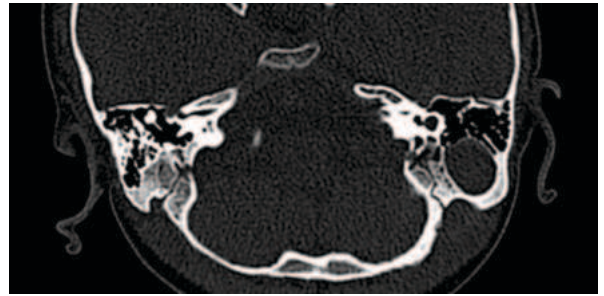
Axial CT image showing right cochlear aplasia and left common cavity.
